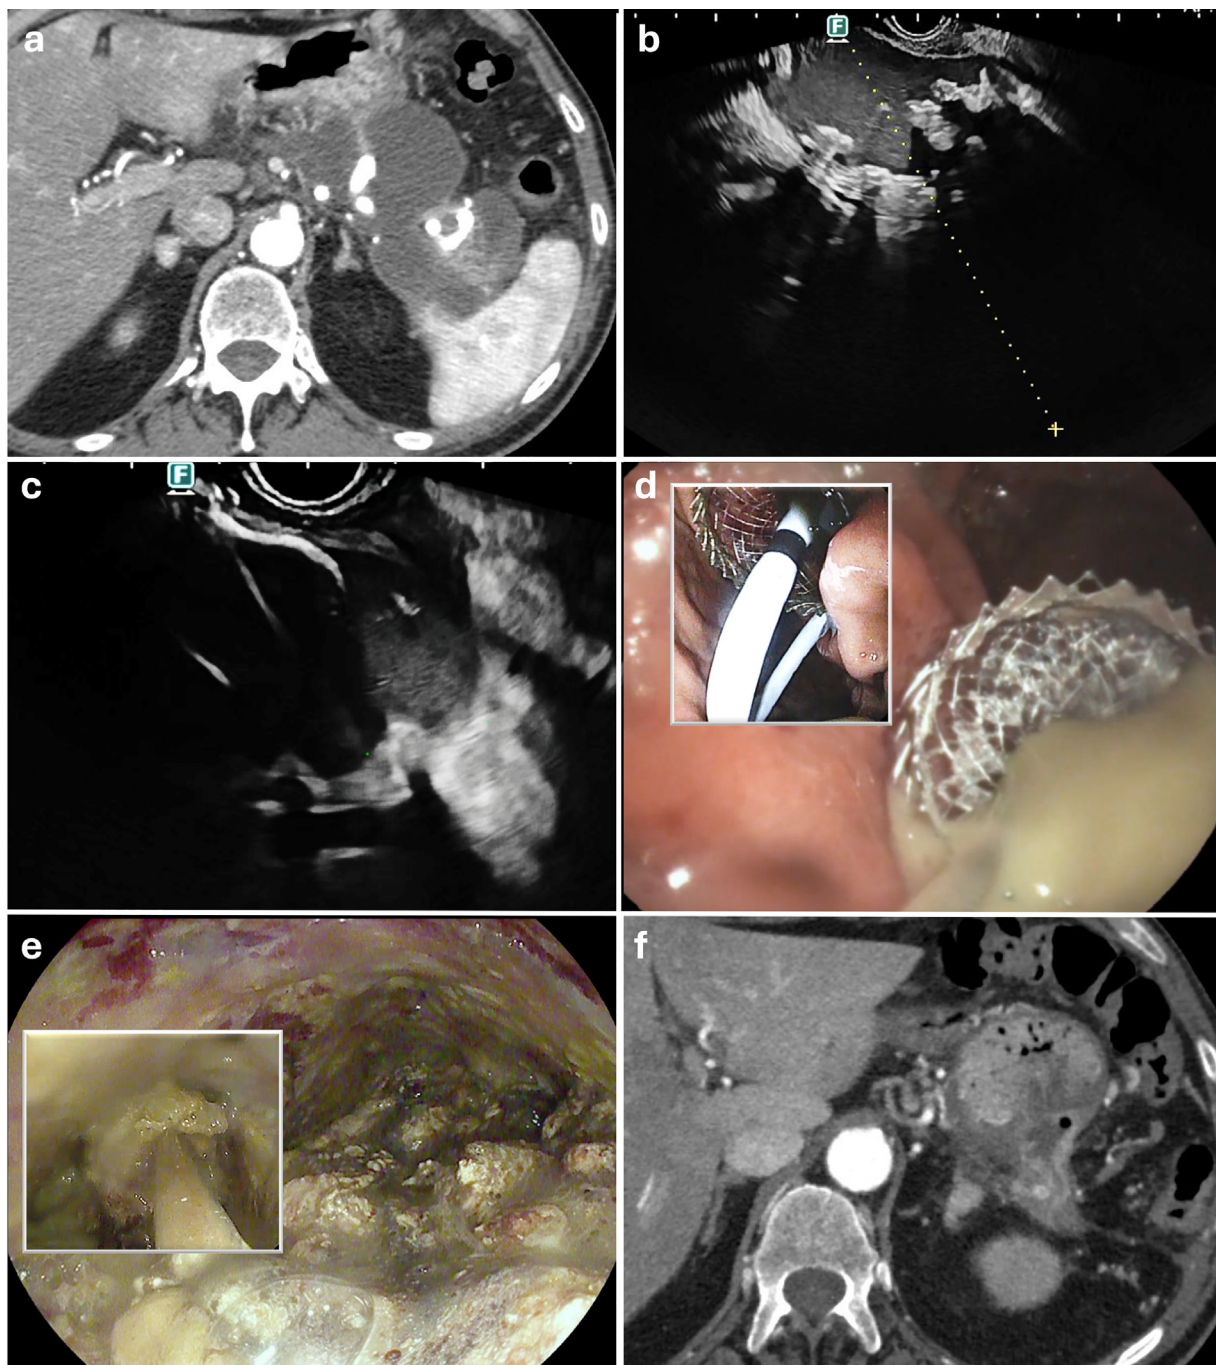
Post-Pancreatitis Collections: a) CT scan of a Walled Off Necrosis following necrotizing acute pancreatitis; b) EUS showed a large fluid collection, where the fluid part occupied a small volume, whereas the majority of the collection was occupied by hyperechoic necrosis (>60%); c) an electrocautery-enhanced Lumen Apposing Metal Stent (LAMS) was advanced free-hand; d) flow of purulent and necrotic material at release of the gastric flange, followed by placement of a coaxial double pigtail plastic stent to prevent LAMS obstruction; e) direct endoscopic necrosectomy (DEN) was required due to non-improving symptoms; j) final CT scan showing resolution of the collection after DEN and LAMS removal.
